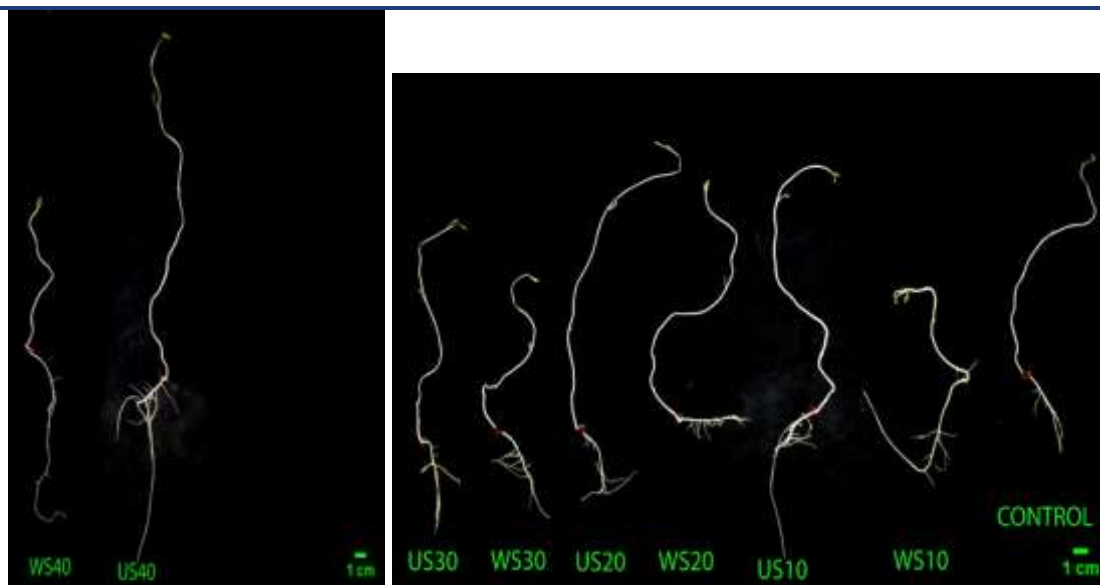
The morphology of common vetch seedlings after water soaking (WS) and ultrasound (US) treatments (after 14 days of germination)
